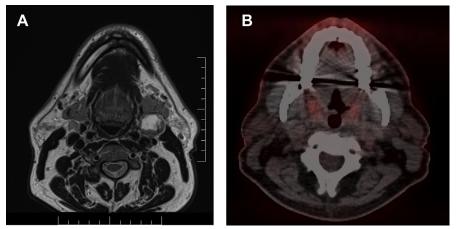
(*A*) MRI scan of patient with left-sided nodal disease and no obvious primary site. (*B*) PET/CT of the same patient with a report suggestive of a tongue base primary tumor. The final pathology demonstrated a palatine tonsil and contralateral tongue base synchronous primary tumors.
